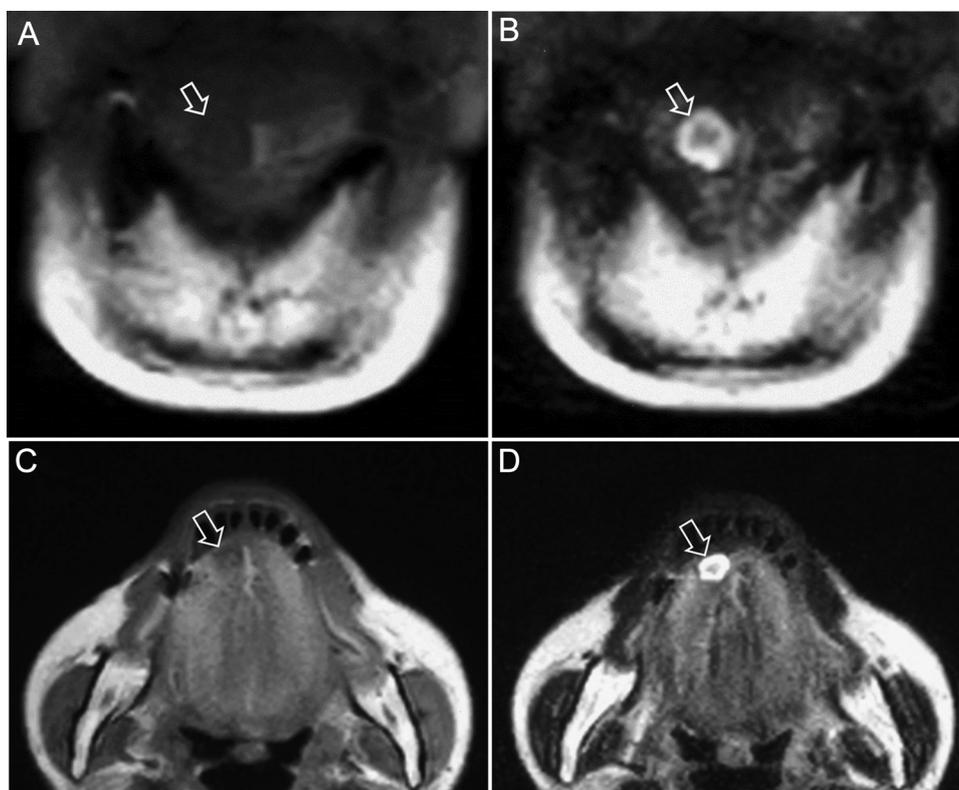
Frontal cross-sectional and horizontal-section of MRI findings.
